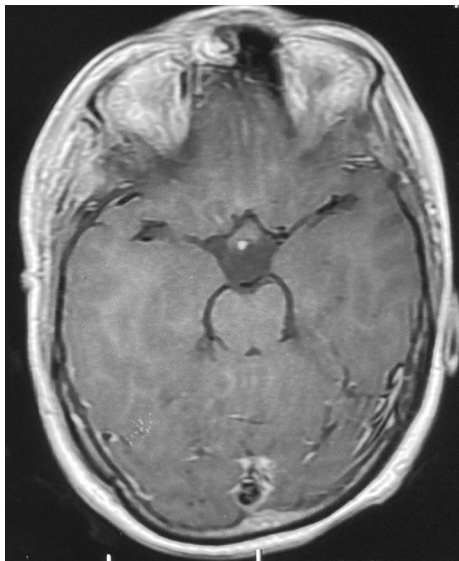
Post-operative MRI axial section showing complete removal of the lesion
